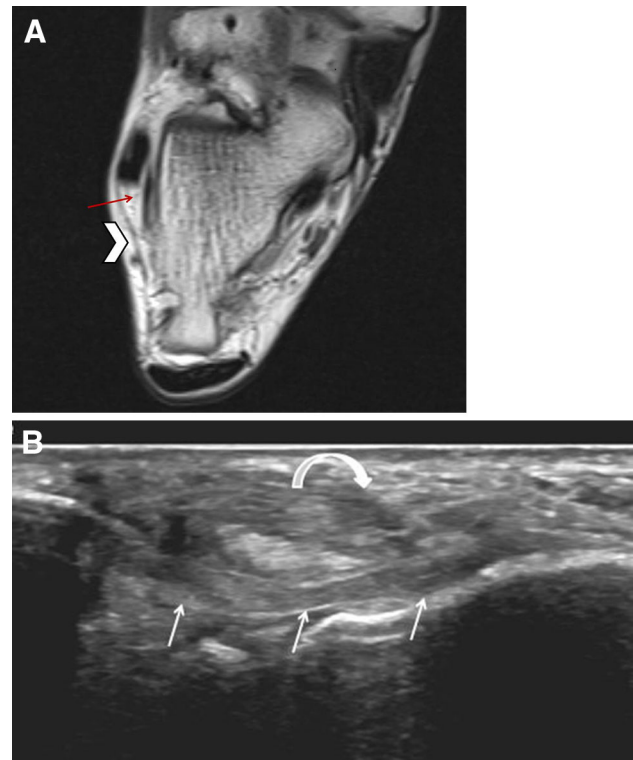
T1-weighted axial MR image (a) depicting the calcaneofibular ligament (*arrow*) that lies deep to the peroneal tendons and runs from the summit of the lateral malleolus to the outer aspect of the calcaneal body. The inferior retinaculum is superficial to the peroneal tendons (*arrowhead*). Coronal sonographic image of the submalleolar region (oblique-external) (b) shows the calcaneofibular ligament (*arrows*) running beneath the peroneal tendons (shown in cross section, *curved arrow*), from the summit of the lateral malleolus to the body of the calcaneus. The patient’s foot should be dorsiflexed to place maximal tension on the ligament
